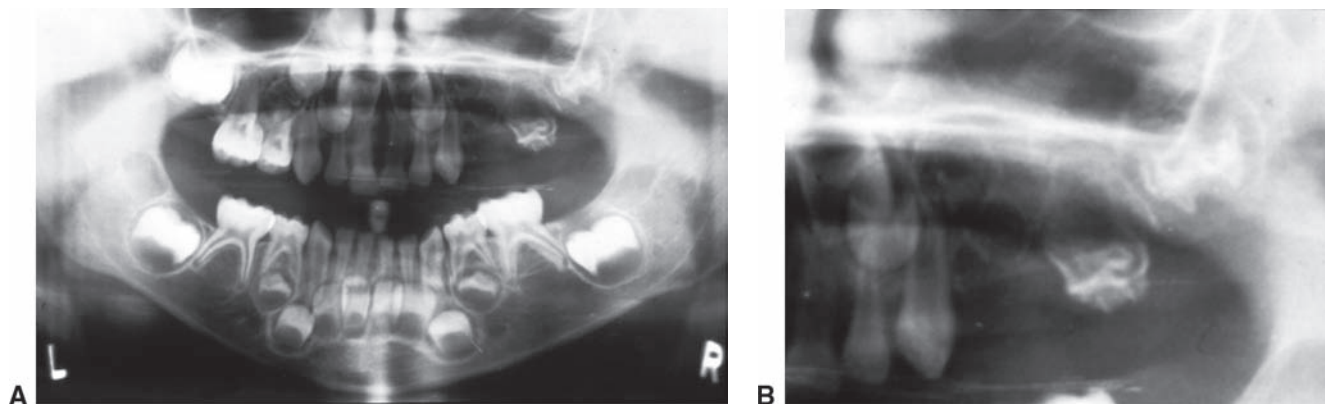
Regional odontodysplasia. A. The panoramic radiograph shows that the affected teeth are limited to the right posterior maxillary quadrant. B. A close-up view of the right maxilla reveals that the premolar and molar teeth are all affected. Note the irregular outlines of the crowns of the molar teeth.
